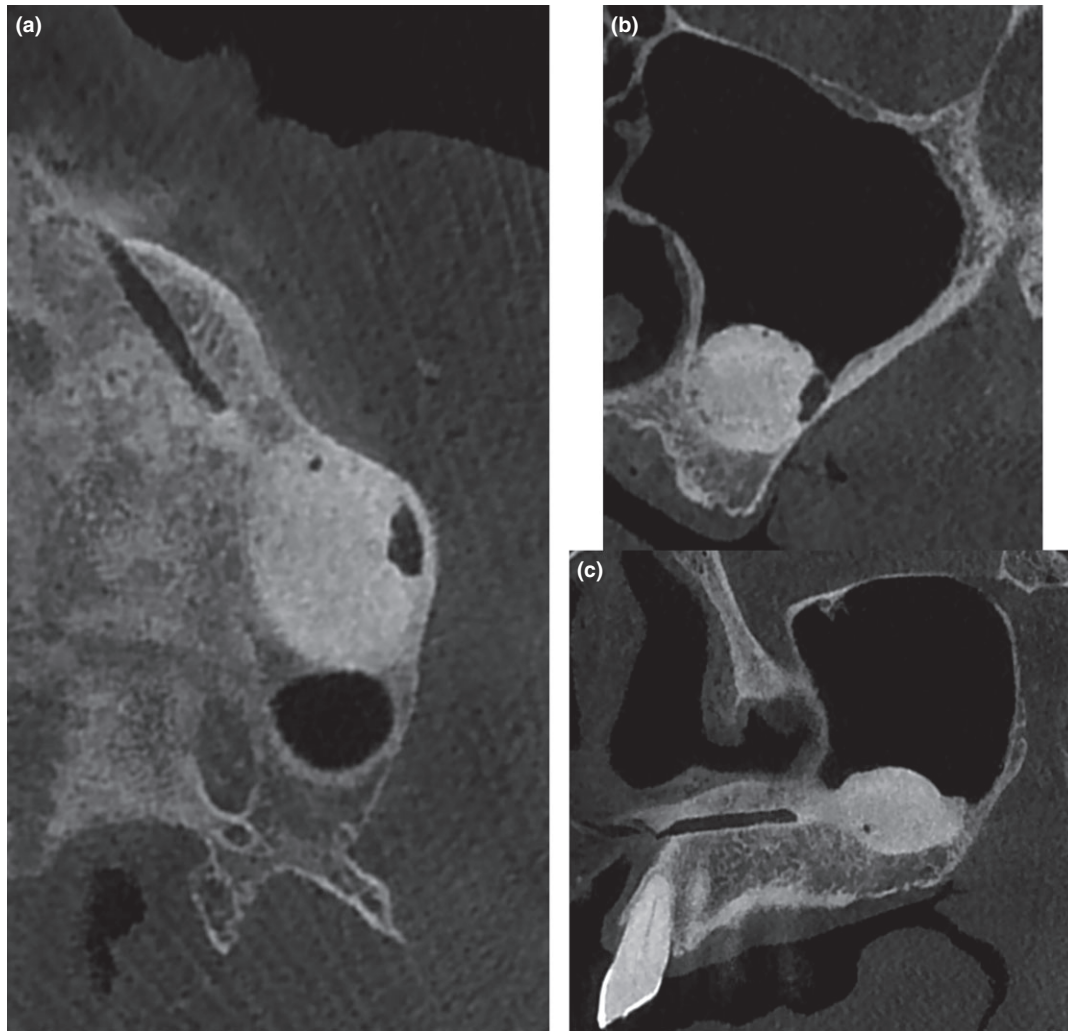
Post-operative Cone beam CT (axial, coronal, and sagittal views). A dome-shaped appearance confirms procedure success without perforation (b). The needle approach is visible in axial section as a boneless line (a). The membrane elevation and the submucosal filling material occupy the edentulous maxillary sinus floor (c). No sinus complication occurred in this case of radiological sinus lift.
